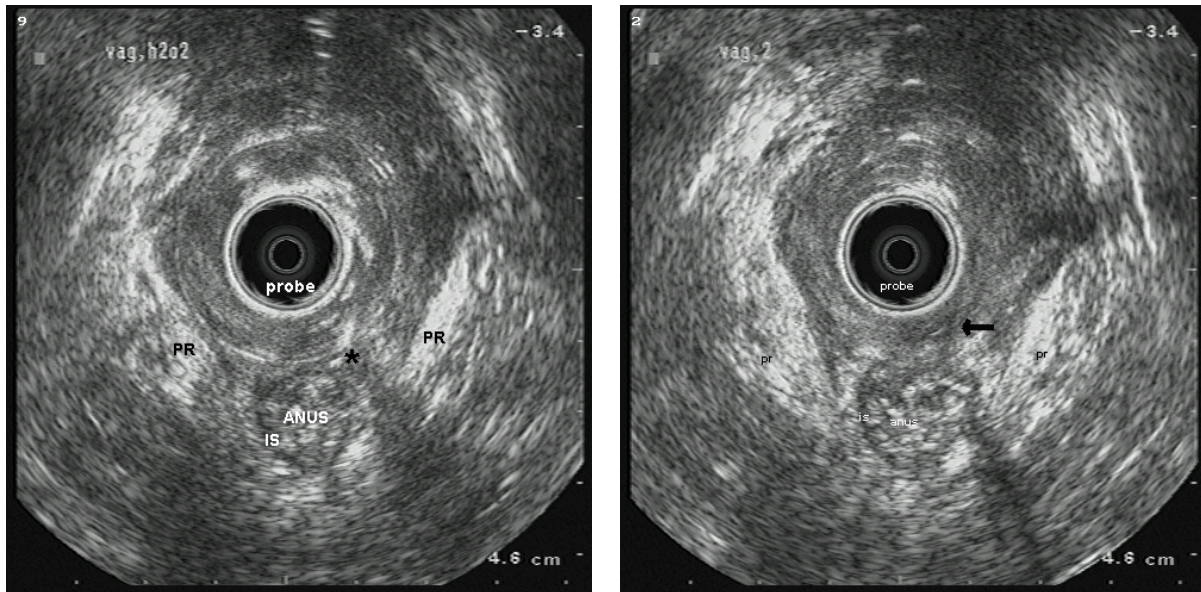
A) Transvaginal ultrasound shows a defect in the rectovaginal space suggestive for a fistula (Arrow). B) After injecting hydrogen peroxide in the fistula opening which is located in the vaginal introitus, an anovaginal fistula is visualized with the fistula opening at the level of the puborectalis muscle (Asterisk). The probe is situated in the vagina, and the anus shows dorsally. IS internal sphincter; PR puborectalis muscle.
